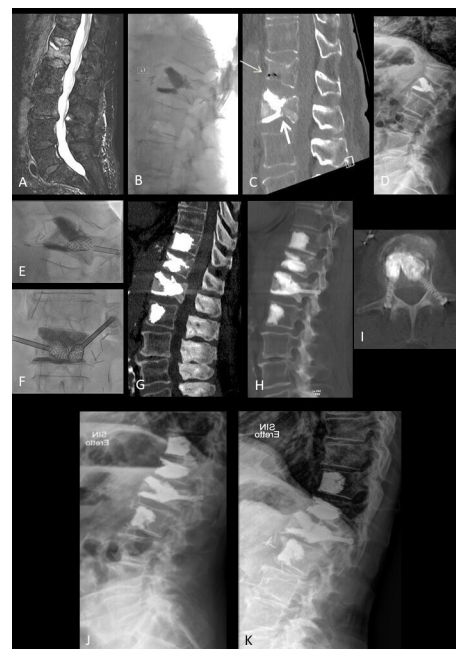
Patient 2. (A) T2-weighted fat-suppressed MRI showing fracture of L1 with bone marrow edema and large osteonecrotic cleft in the vertebral body, subsequently treated with vertebral augmentation (B). (C–D) CT scan and standing plain film 2 weeks later showing middle column collapse at L1 (thick arrow on C) and a new fracture of T12 (thin arrow on C), with local kyphotic deformity (D). (E–F) Procedural fluoroscopic orthogonal views of the modified stent-screw assisted internal fixation (SAIF) of L1: 4.5 mm bilateral transpedicular trocars and small-size vertebral body stents are inserted and balloon expanded in the posterior part of the vertebral body. (G–I) Post-procedure CT scan showing reconstruction of L1 middle column with modified SAIF technique, vertebral body stent expansion and partial fracture reduction of T12 and prophylactic augmentation of T11 and L2. Standing plain films showing stable result at 1-month (J) and 6-month (K) follow-up, respectively.
